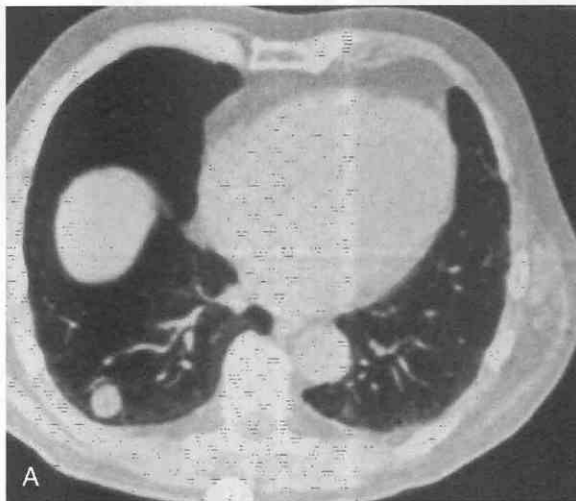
A–C, Pulmonary hamartomas. CT can be used to identify fat within these two nodules (*arrows*).
